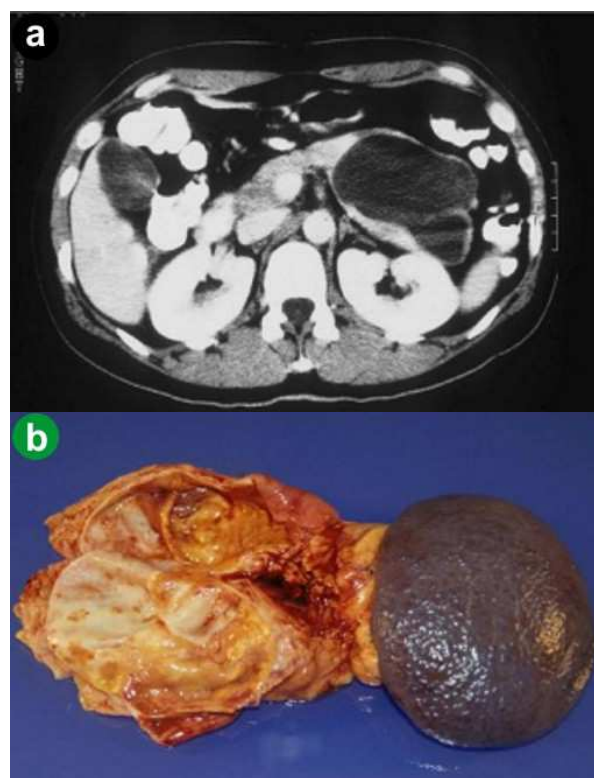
a. Axial CT shows cystic tumor in the pancreas tail (8.5 cm diameter). b. Gross appearance of the cystic mass. The circumscribed lesion involves the tail of the pancreas.
